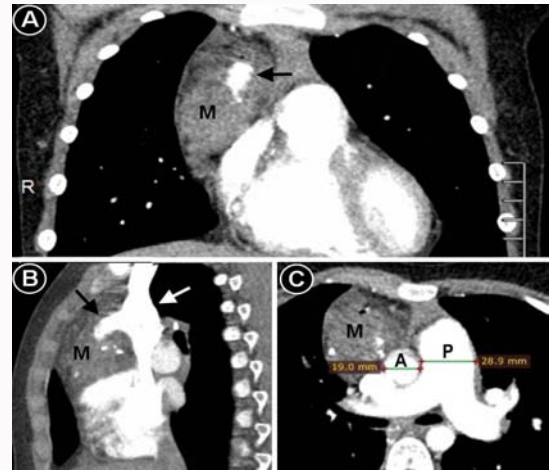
Arterial phase of contrast enhanced computed tomography showing only mild enhancement of the mediastinal mass (M). A large vein in the center of the mass (pointed by a black arrow) was filled with contrast retrogradely from superior vena cavae (pointed by a white arrow), the contrast being injected into a vein of the right arm. The pulmonary artery (P) appears prominently dilated compared to ascending aorta (A), the findings being consistent with pulmonary hypertension. Panel A – coronal view, panel B – sagittal view, panel C – axial view.
